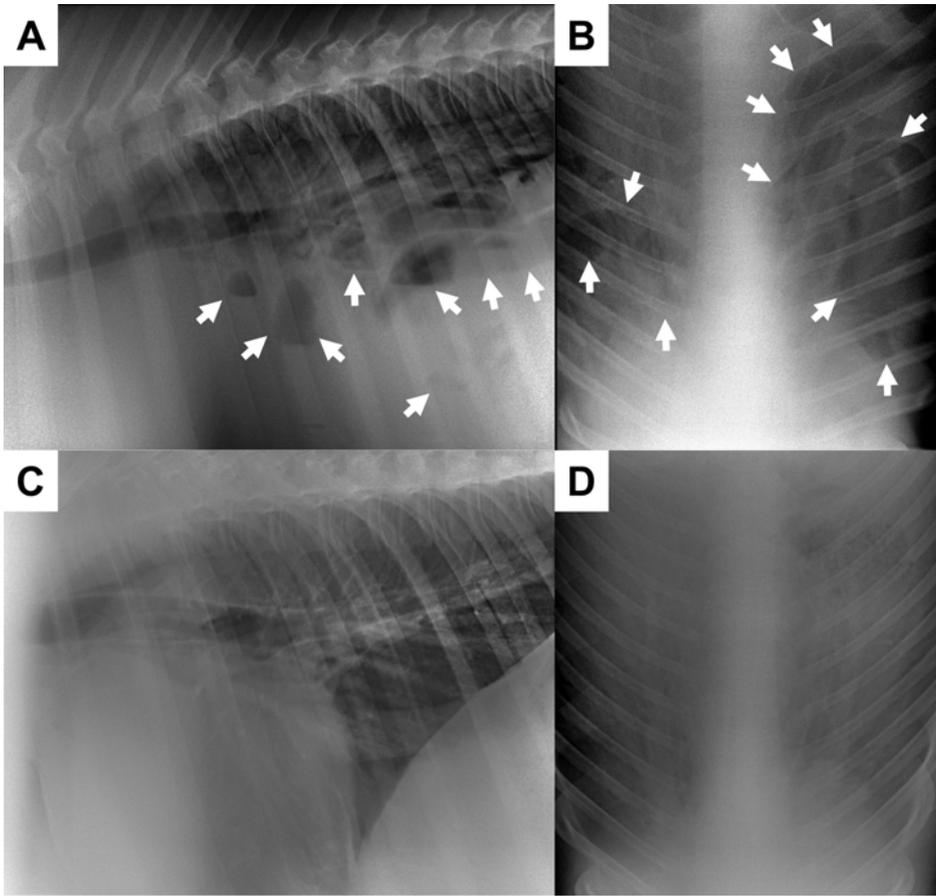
Radiographic images of the thoracic cavity in this study. (A, B) Preoperative thoracic cavity images: the presence of pleural effusion and herniating loops of the small intestine into the left and right thoracic cavities is evident (white arrows). This is accompanied by the loss of the cardiac silhouette and diaphragmatic line. (C, D) Postoperative thoracic cavity images: the pleural effusion and herniating loops resolved after surgery, leading to the clear visibility of the cardiac silhouette and diaphragmatic line.
